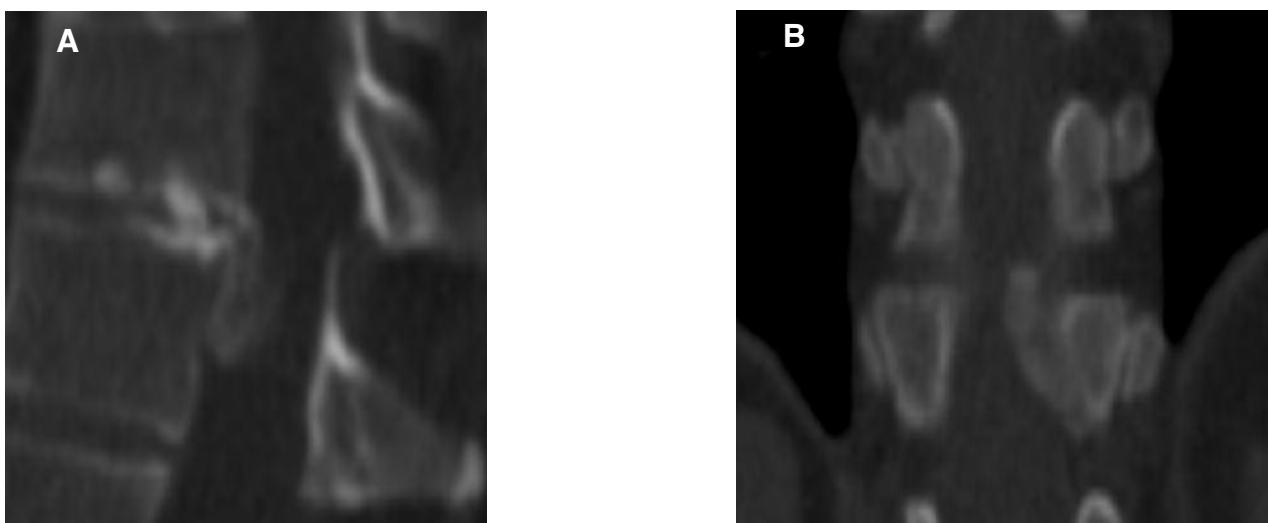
(A) Sagittal and (B) coronal CT reformats show that the abnormality is contiguous with the T11/12 disc and is consistent with an extruded disc, emanating from the T11/12 level. It shows heavy calcification of its periphery (corresponding to the T2 low signal shown on MRI).
